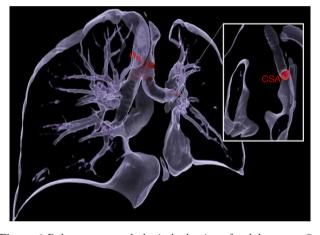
Pulmonary morphological adaption after lobectomy. Θ_R , right tracheobronchial angle; Θ_L , left tracheobronchial angle; dotlines, carinal plane; *, residual lobar bronchus. CSA, cross-section area [chest CT with 20 mm MPVR. Case of a previous pulmonary left upper lobectomy. ® "SS. Annunziata" University Hospital of Chieti (Italy) – Department of General and Thoracic Surgery.
